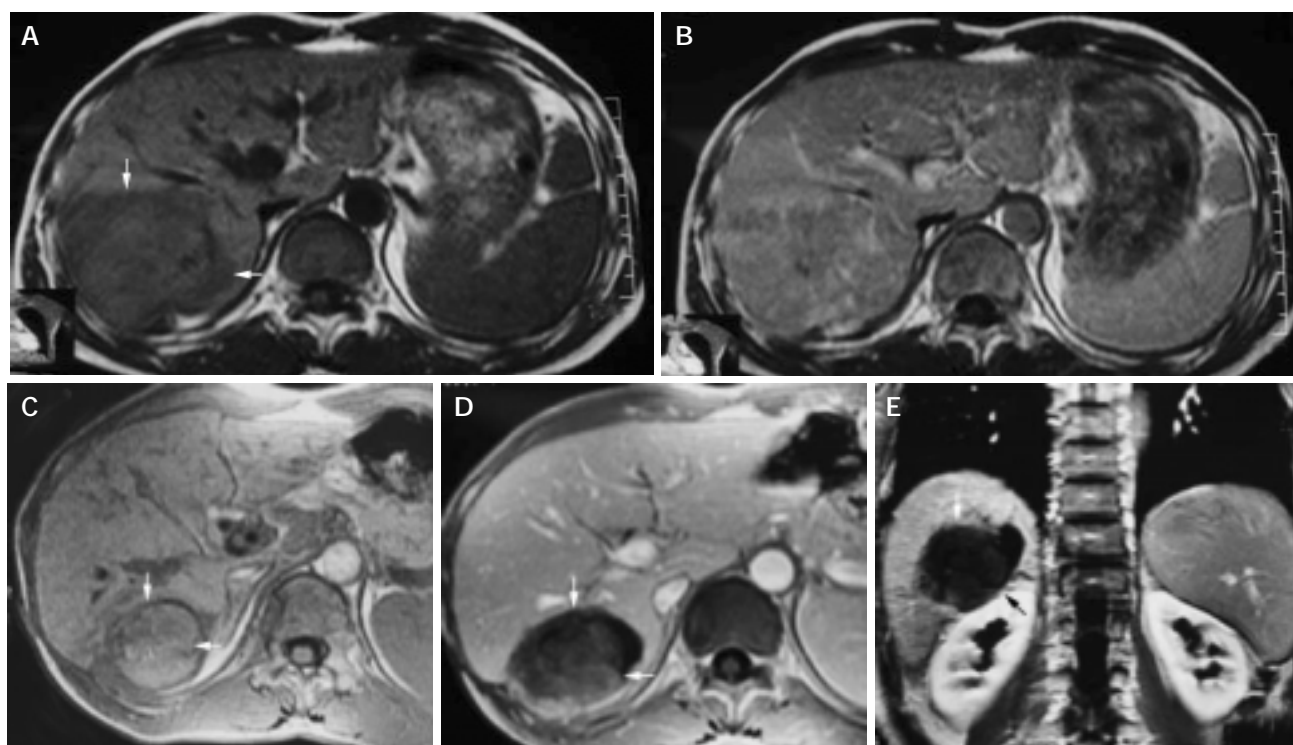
A 42-year-old male with hepatocellular carcinoma. A: MRI T₁-weighted images before HIFU treatment showed that liver tumor of right-posterior lobe was 115 mm×100 mm×66 mm; B: MRI enhanced imaging before HIFU revealed that enhancement of mass in liver right-posterior lobe was higher than that of surrounding normal liver tissues; C: MRI T₁-weighted imaging 11 mo after HIFU revealed that liver tumor of right-posterior lobe obviously decreased in size (50 mm×55 mm×60 mm); D, E: MRI enhanced imaging (cross section and coronal section) 11 mo after HIFU revealed that liver tumor had shrunk obviously, blood supply of tumor was eliminated, the tumor therapeutic region had coagulation necrosis.
